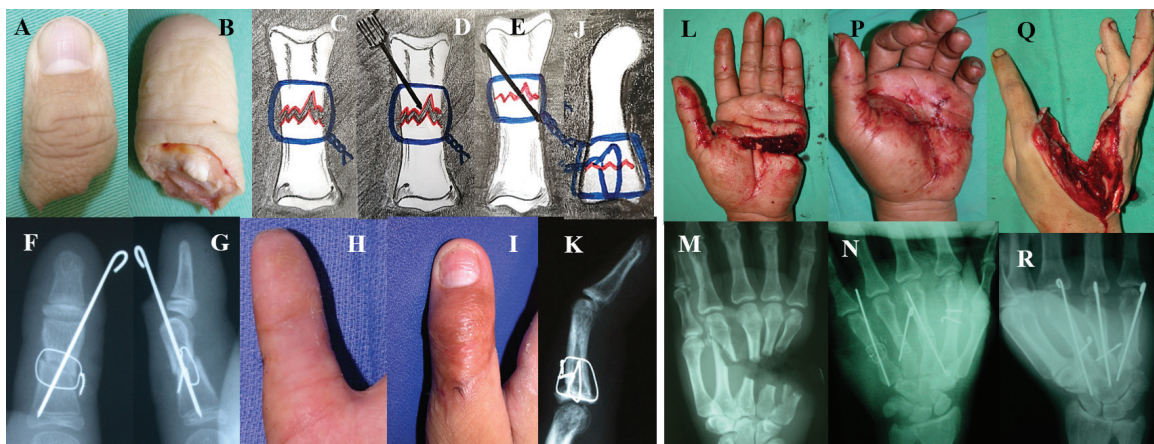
A, B: a complete amputation of the right thumb in a 10 year old. C: the cerclage wire (0.4 mm) is placed in position around the fractured bone ends as shown and twisted. D: an appropriately sized cross K-wire is then passed through the first cortex but not through the fracture site. E: the bone ends are approximated and the wire tightened (a drill may be used for this) with care so as not to break it. The K-wire is then pushed through as reinforcement. F, G: on x-ray. H, I: clinical picture at 3 months. J, K: if no K-wire is used but two cerclage wires are placed at 90° to each other. L, M: a transverse transmetacarpal partial amputation. The metacarpal area has a lot of structure packed tightly together making this a challenging surgery. Minimal and rapid fixation is key to avoid muscle ischemia as well. N, P: Lister's wiring may be used or Q, R: cross K-wires.
